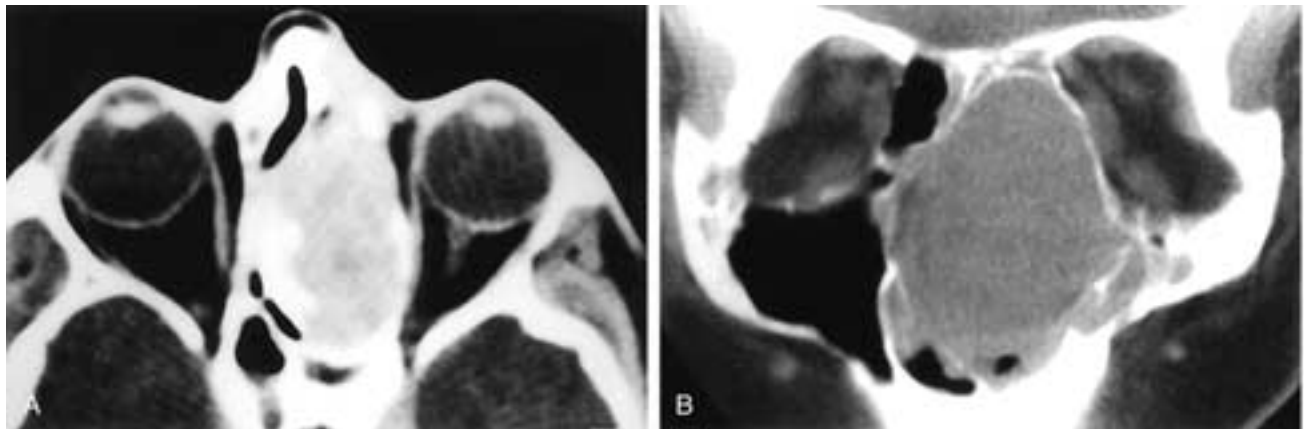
Axial CT scan (A) shows an expansile, homogeneous mass in the left ethmoid sinuses that has remodeled the surrounding bone. Coronal CT scan (B) on another patient shows a large, expansile mass in the left nasal fossa and ethmoid sinuses. The left antrum and right ethmoid sinuses are obstructed by the mass. The surrounding bone is remodeled rather than destroyed. Both of these patients had a schwannoma. Also see [Fig. 6-7C](#).
